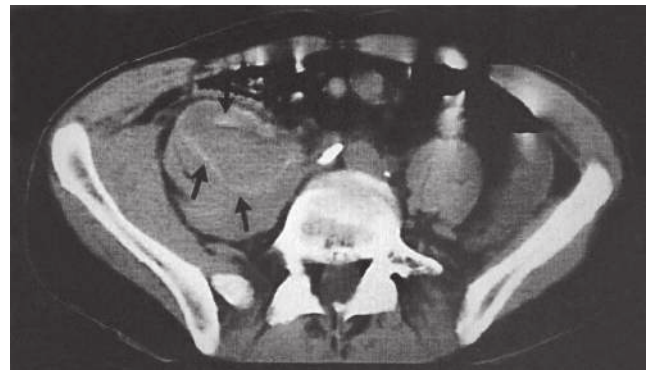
Retroperitoneal hemorrhage. Axial computed tomographic scan of the pelvis shows hematoma (arrows). Lumbar plexopathy may result from hemorrhage into the retroperitoneal space, most often as a complication of anticoagulation or in association with hemophilia or other coagulation disorders. These hematomas usually are located within the psoas muscle itself, where they can compress the lumbar plexus below. (From Lindner, A., Zierz, S., 2001. Retroperitoneal hemorrhage. *N Engl J Med* 344, 348. With permission.)
